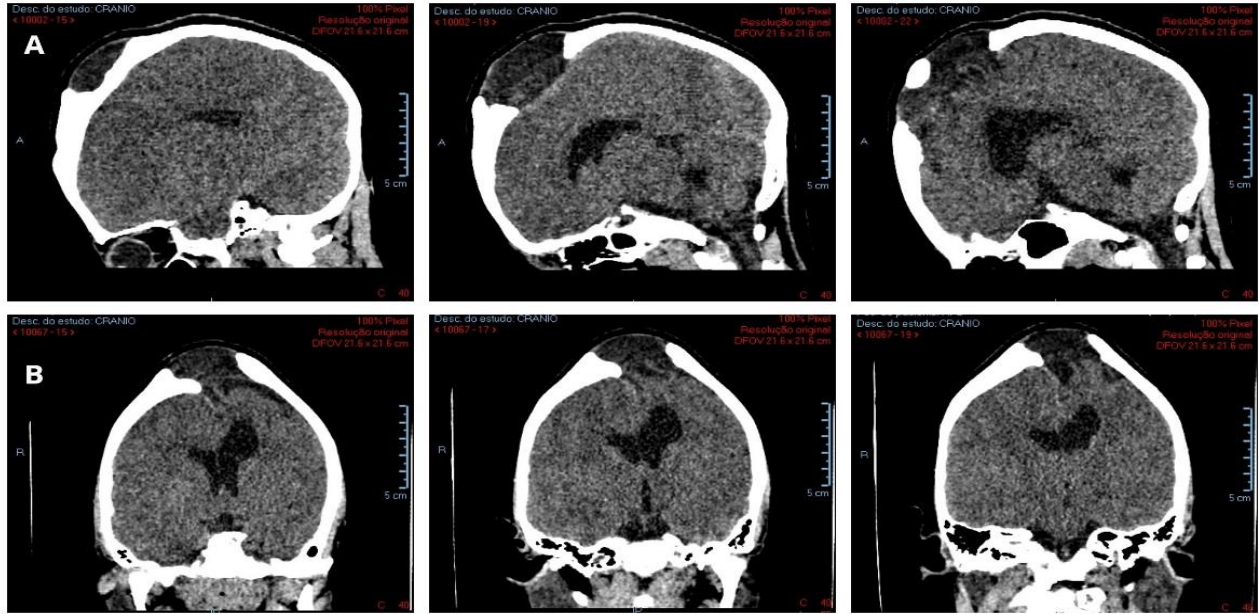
Sagittal (A) and coronal (B) skull computed tomography showing an arachnoid cyst in the frontal lobe protruding into the skullcap, reduced volume cistern and slightly ectasied centered ventricle.
